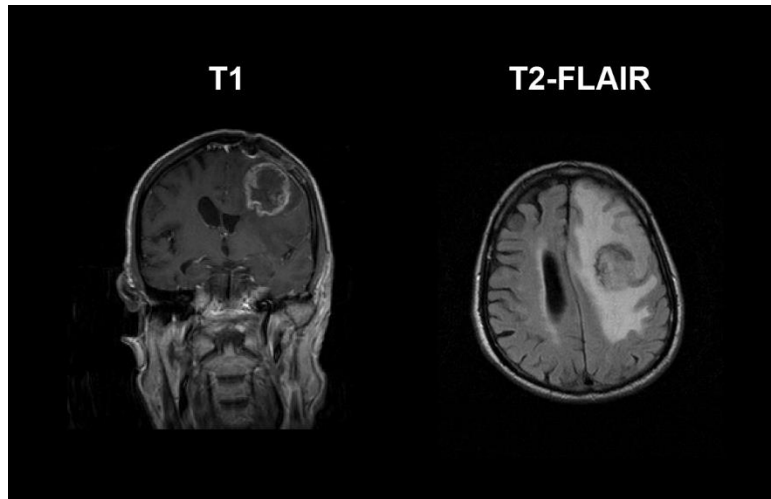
Post-biopsy Magnetic Resonance (MR) images from patient GBP03. On the left, a coronal T1-MR image where the highly necrotic ring-shaped lesion can be seen frontotemporally in the left hemisphere, near motor area. Notice the mark of biopsy cavity formed by the trepanation of the skull. On the right, an axial T2-FLAIR MR image is shown, where the bright peritumoral infiltrative edema is remarkably extended causing space-occupation of the left hemisphere and internal pressing of the lateral ventricle.
